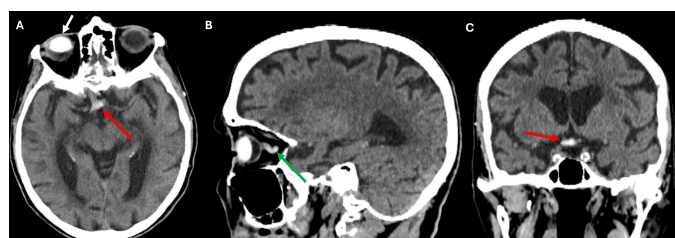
Noncontrast axial (A), sagittal (B), and coronal (C) computed tomography images. Hyperdense intraocular material consistent with silicone oil is observed in the right globe (white arrow, A). Hyperdense foci representing migrated silicone oil are observed at the optic chiasm level (red arrows, A and C). In addition, a hyperdensity consistent with silicone oil is observed along the right optic nerve course (green arrow, B).
